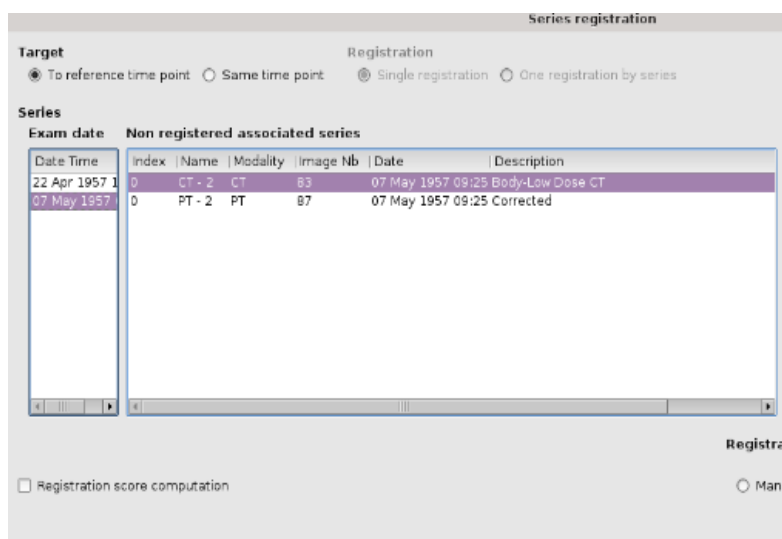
Choosing the CT scans to perform registration on. The process needs to be repeated to perform in on both CT scans (MAA and PET)
